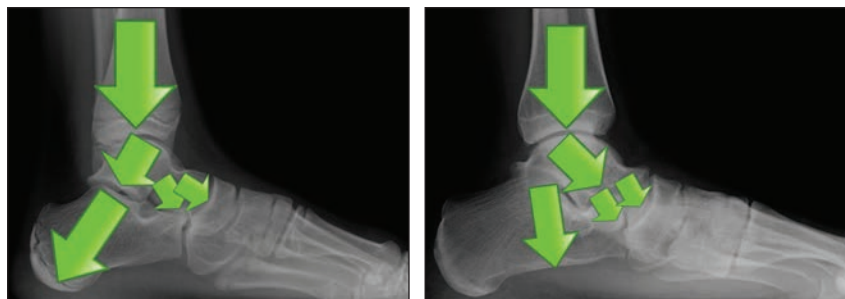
Weight-bearing lateral radiograph showing an aligned talotarsal joint. Arrows indicate the normal force distribution. 1-B shows talotarsal joint displacement with arrows showing abnormal force distribution anteriorly.
